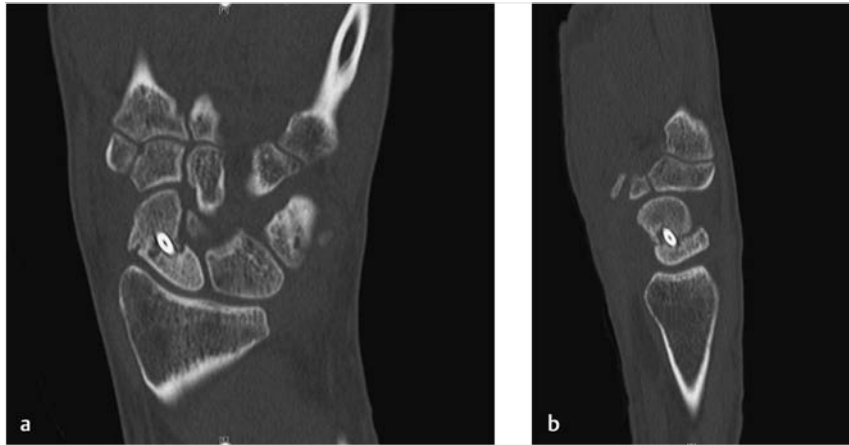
(a, b) Radiographs and a CT scan failed to show signs of bridging across the fracture sight.
